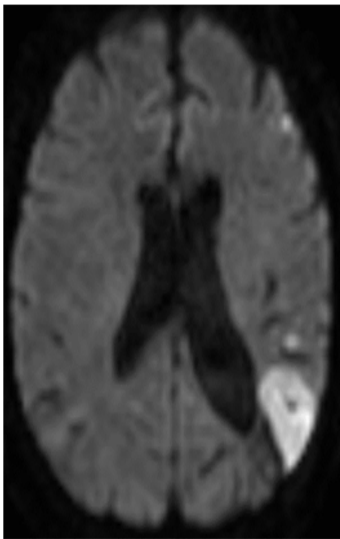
MRI reveals acute left parietal infarct
